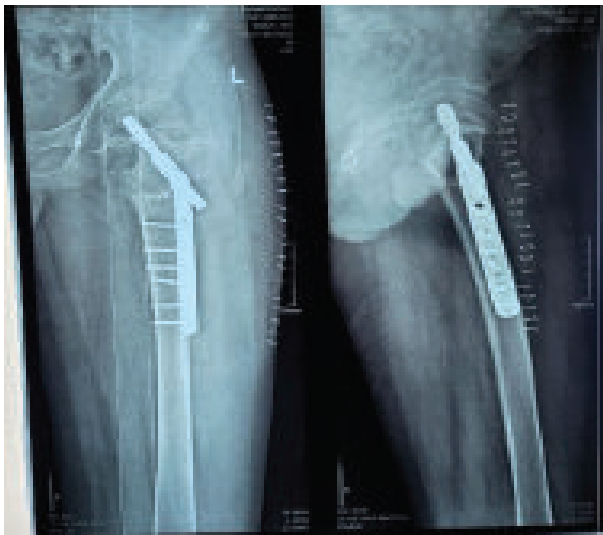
Postoperative X-rays demonstrating valgus osteotomy correction and stable DHS fixation
